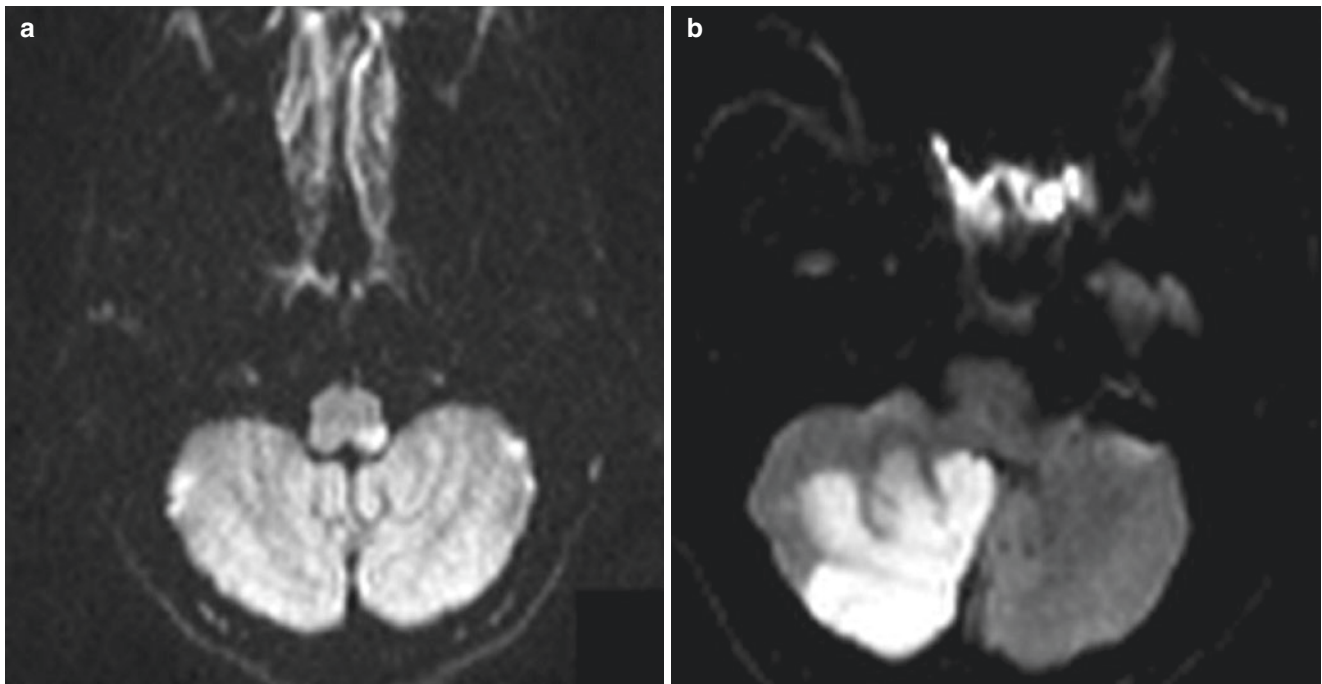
Lateral medullary/PICA infarction. (a), DWI shows acute infarction of left lateral medullary pyramid. (b), In a different patient, DWI shows a large infarction of the right inferior cerebellar hemisphere and vermis. Both patients have vertebral occlusion on MRA
